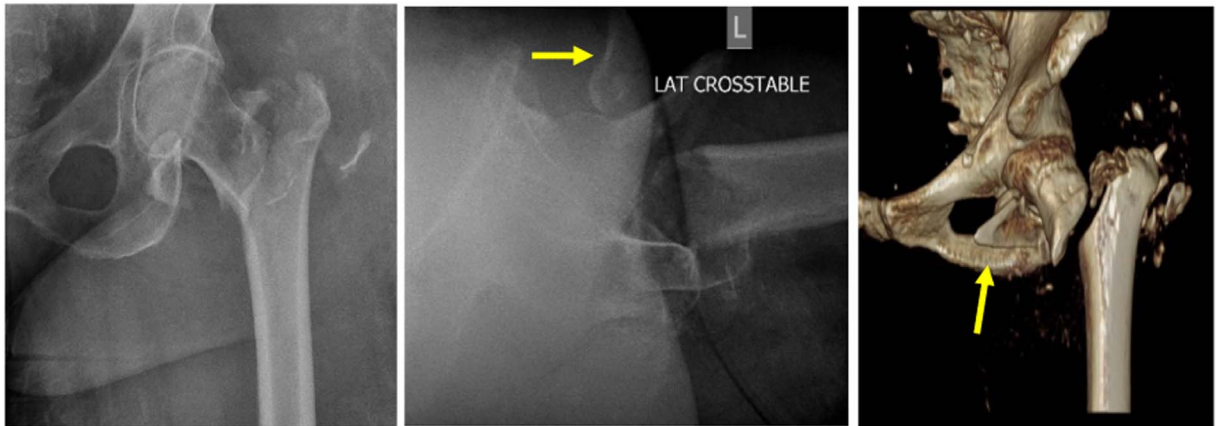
Preoperative films and CT showing unstable intertrochanteric fracture. The lesser trochanter was markedly displaced with its sharp spike turning anteriorly (arrows).
